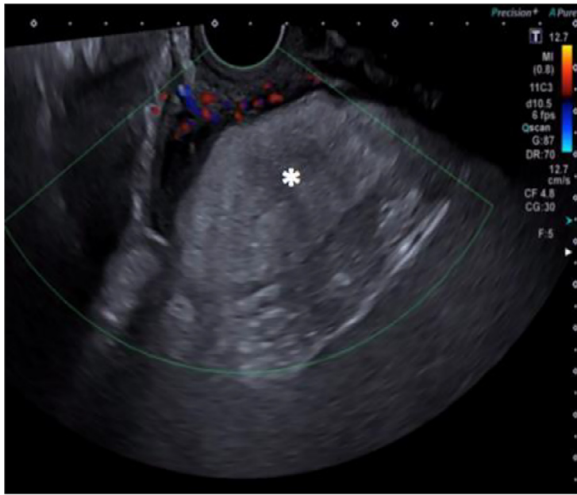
Transvaginal ultrasound: demonstrated a rounded hyperechogenic mass in the left adnexal region (asterisk).
